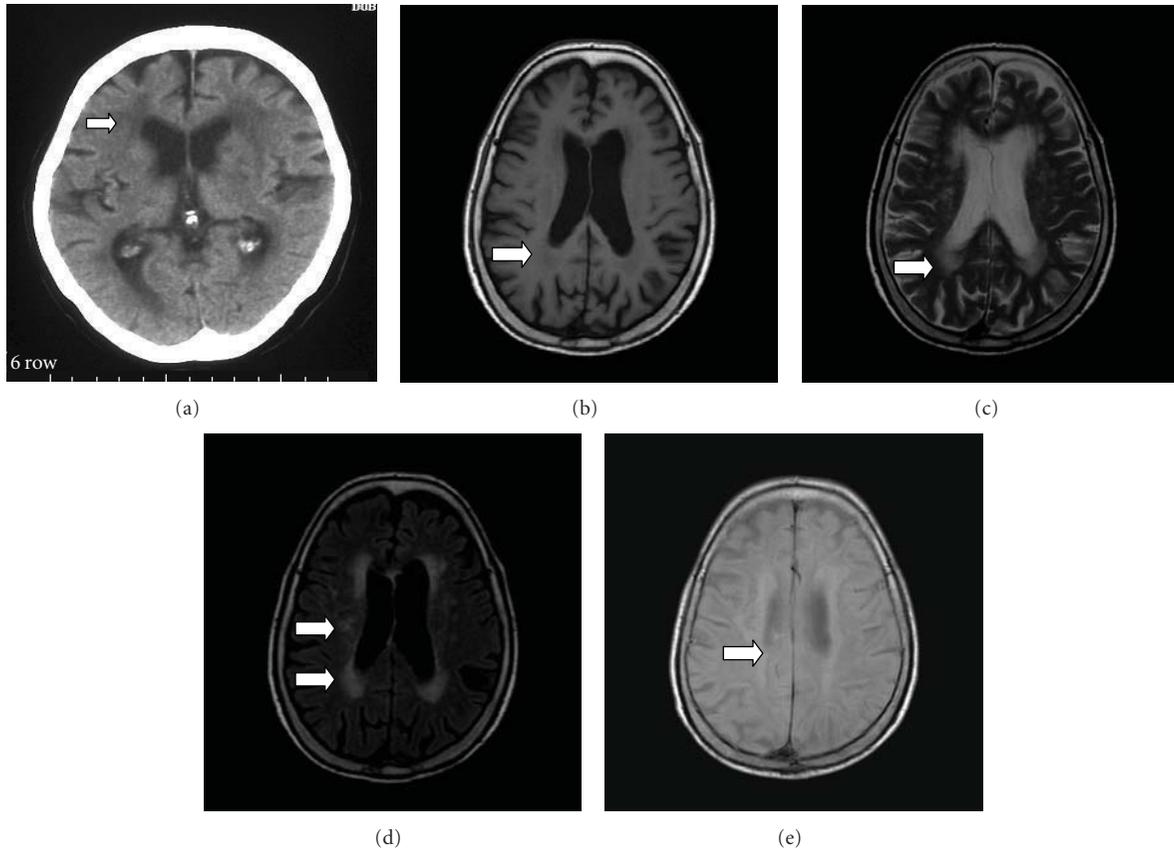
WMC on CT and MRI. (a) Hypodensities on CT; (b) hypointensities on T1-weighted MRI; (c, d, e) hyperintensities on T2-weighted MRI, proton-density, and FLAIR sequences, respectively. (d) The lower arrow shows the PVWMC, and the upper one shows the DWMC.
